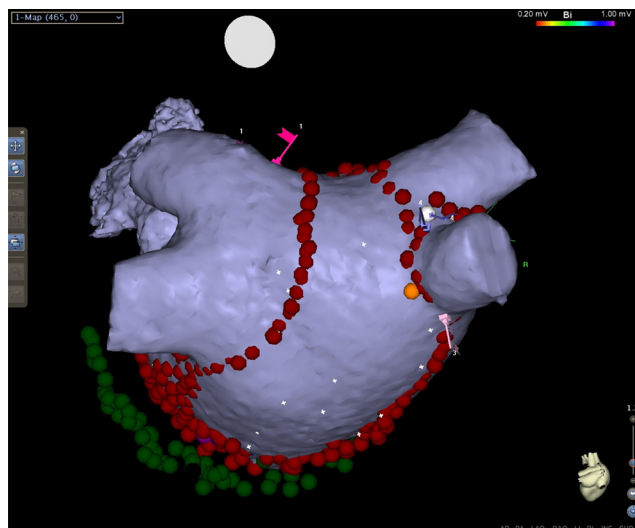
CARTO electroanatomical mapping system. 3D reconstruction of left atrium – CT image integration (CT map only) Catheter ablation for persistent atrial fibrillation. Red dots – ablation points. Green dots – ablation points in coronary sinus. Orange dot – oesophagus in close proximity with posterior wall of left atrium.
